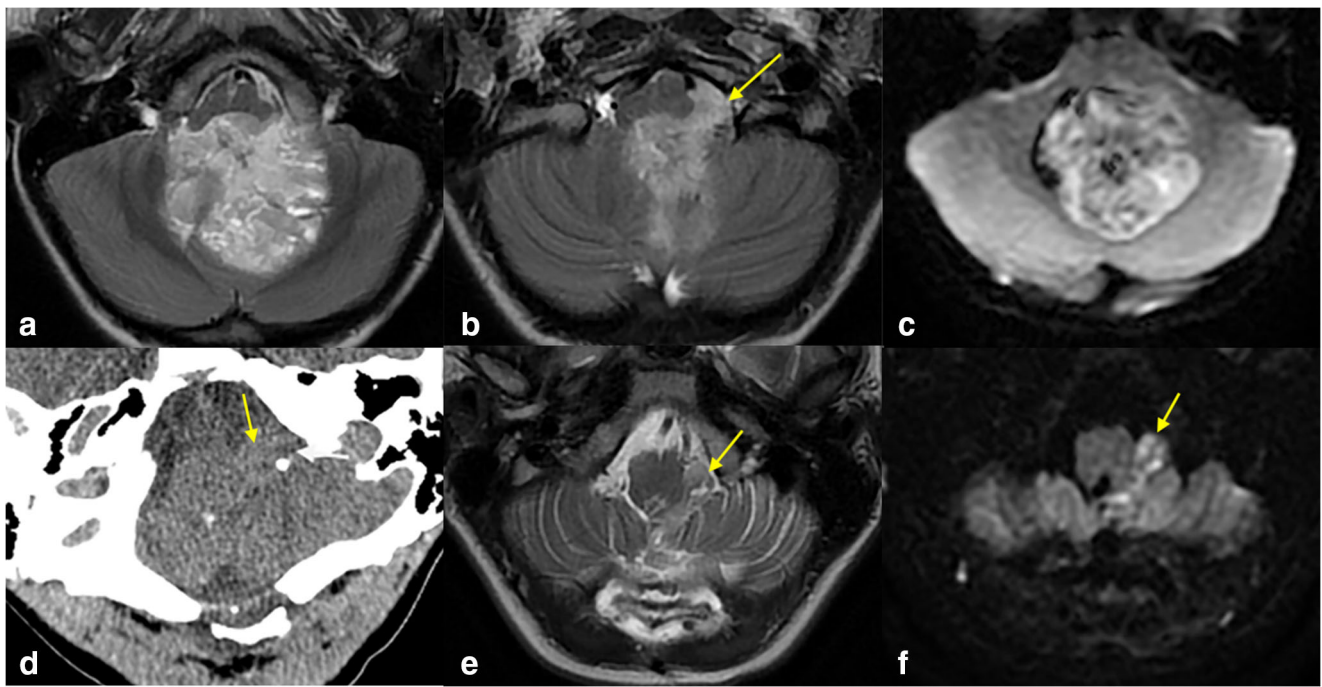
Case 1. MRI; Axial T2 (a, b), and diffusion-weighted imaging (c) shows original tumor in the fourth ventricle extending through the foramen of Luschka on the left. Post-operative CT (d) and MRI (e, f); axial CT (d); T2 (e) and diffusion-weighted imaging (f) of residual tumor extending through the left foramen of Luschka (yellow arrows)
